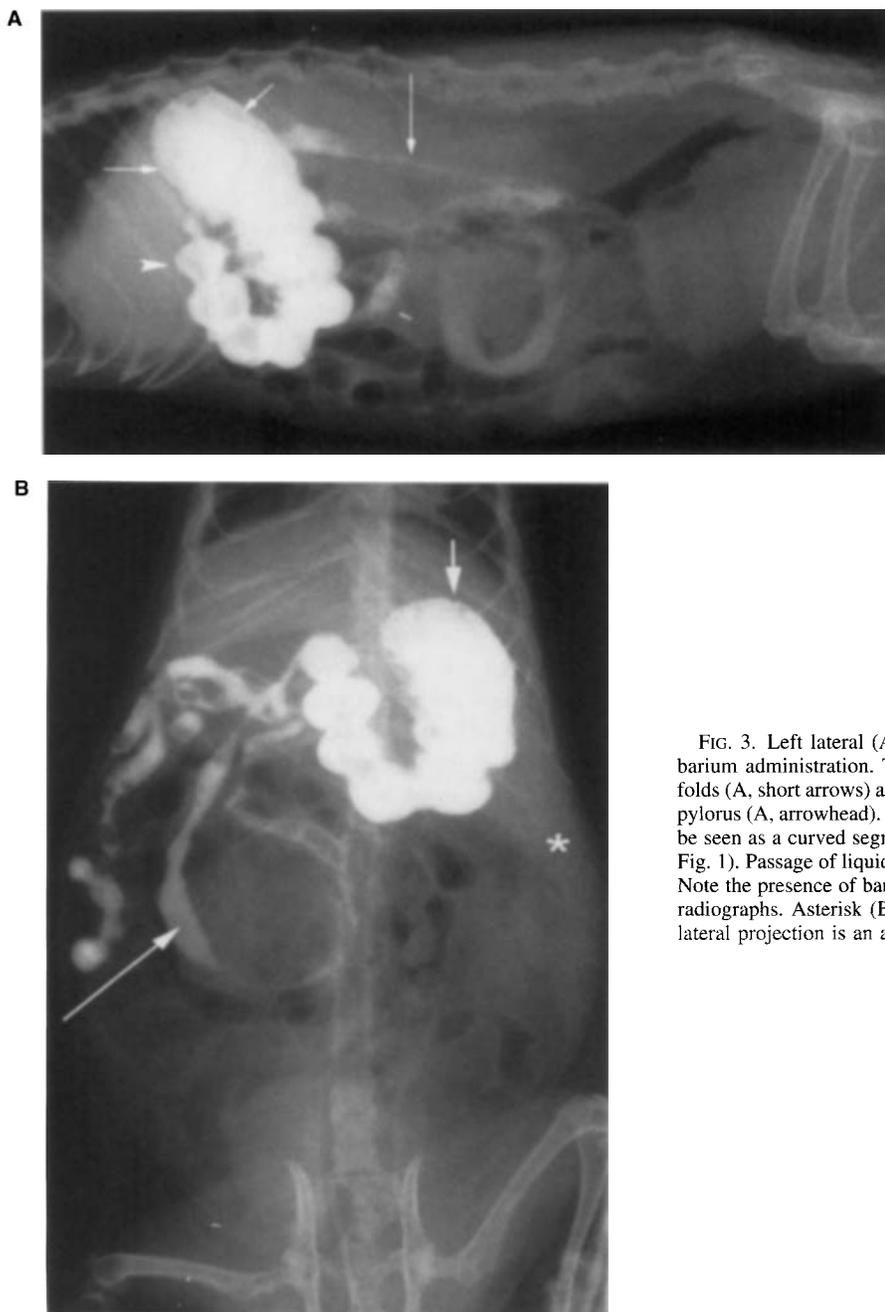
Left lateral (A) and DV (B) radiographs obtained immediately after barium administration. The stomach is filled with barium but the fundic rugal folds (A, short arrows) are still visible. Note the cranial and dorsal position of the pylorus (A, arrowhead). The barium-filled duodenum (A and B, long arrows) can be seen as a curved segment of bowel in the right cranial abdomen (compare to Fig. 1). Passage of liquid barium through the ferret gastrointestinal tract is rapid. Note the presence of barium in the proximal small intestine on these immediate radiographs. Asterisk (B) indicates the spleen. The small linear opacity on the lateral projection is an artifact caused by debris in the cassette.
